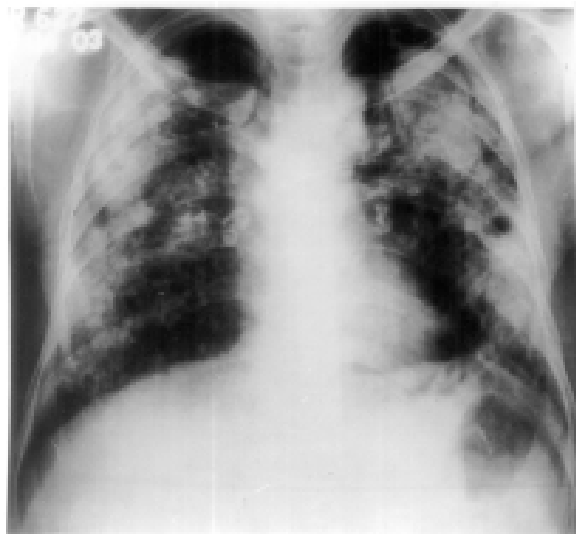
Chest radiograph (postero-anterior view) showing bilaterally extensive disease with large opacities in the upper and mid zones with calcifications. The left upper zone cavity shows an air crescent surrounding a mass with areas of calcifications. The hilar and paratracheal lymph nodes show eggshell calcification.
